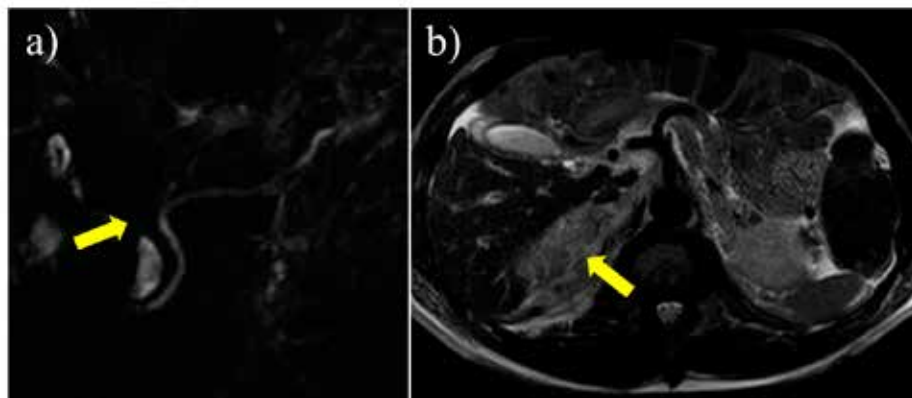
a: Magnetic Resonance Cholangiopancreatography findings. No obvious abnormality in the pancreatic duct. The common bile duct was obstructed (yellow arrow). b: MRI T2 weighted image findings. Soft shadows extended from the right renal portal to the periaortic area. A soft shadow in the area corresponding to the right adrenal gland was also observed (yellow arrow).
